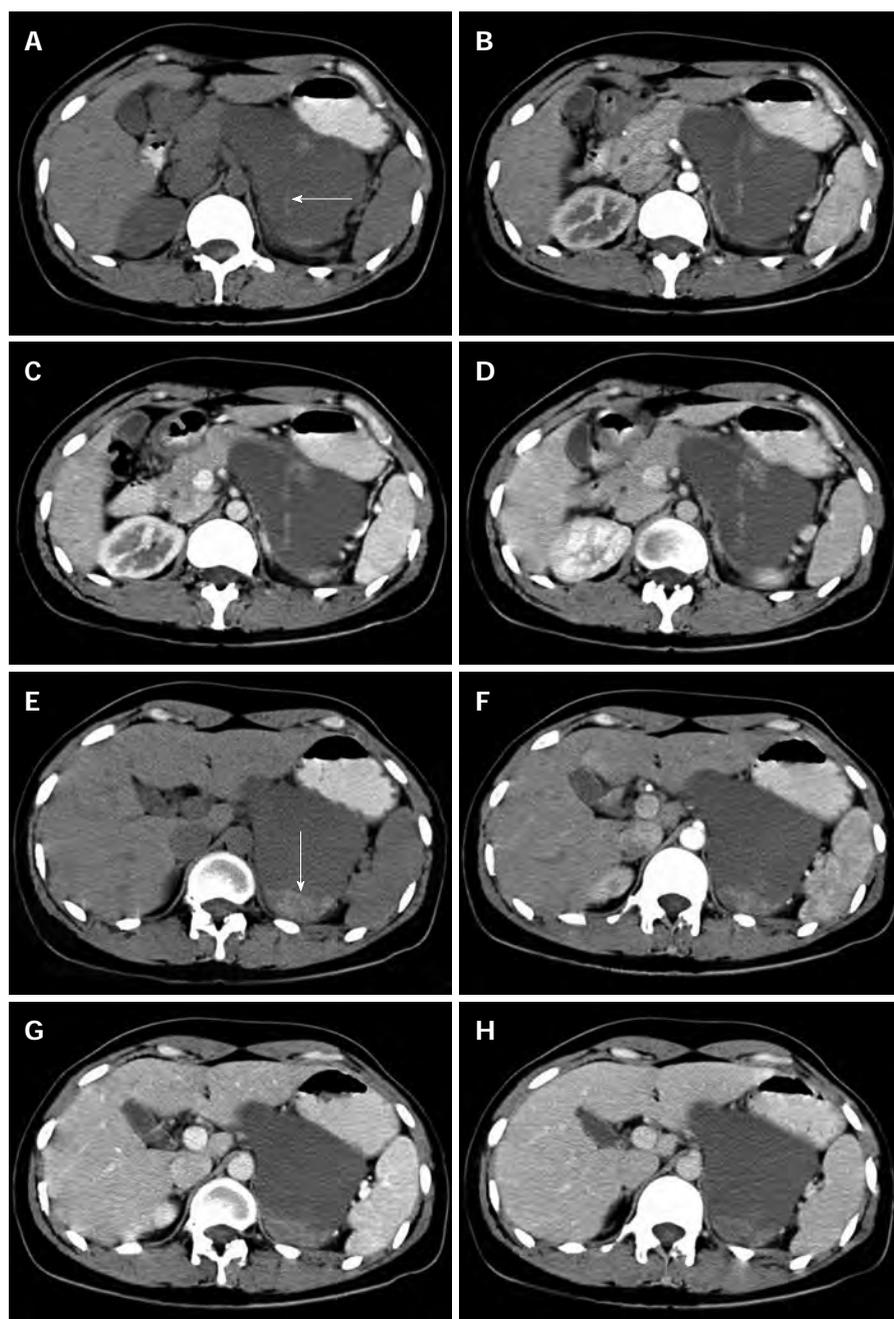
Computed tomography images. A-D: There is a septum (arrow) in the center of the cystic part. Neither the cystic part nor the septum shows enhancement in the arterial phase (20 s after contrast injection) (B), pancreatic phase (45 s after contrast injection) (C), or portal phase (80 s after contrast injection) (D) compared with the pre-enhanced phase (A); E-H: The solid part (arrow) shows no enhancement in the arterial phase (20 s after contrast injection) (F), pancreatic phase (45 s after contrast injection) (G), or portal phase (80 s after contrast injection) (H) compared with the pre-enhanced phase (E).
